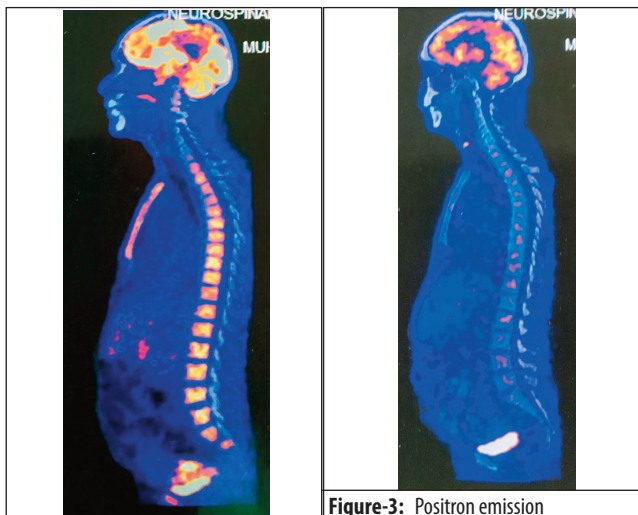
Positron emission tomography-computed tomography (PET/CT) scan showed diffuse marrow uptake in skeletal system (standardized uptake value (SUV) max upto 5.11).
